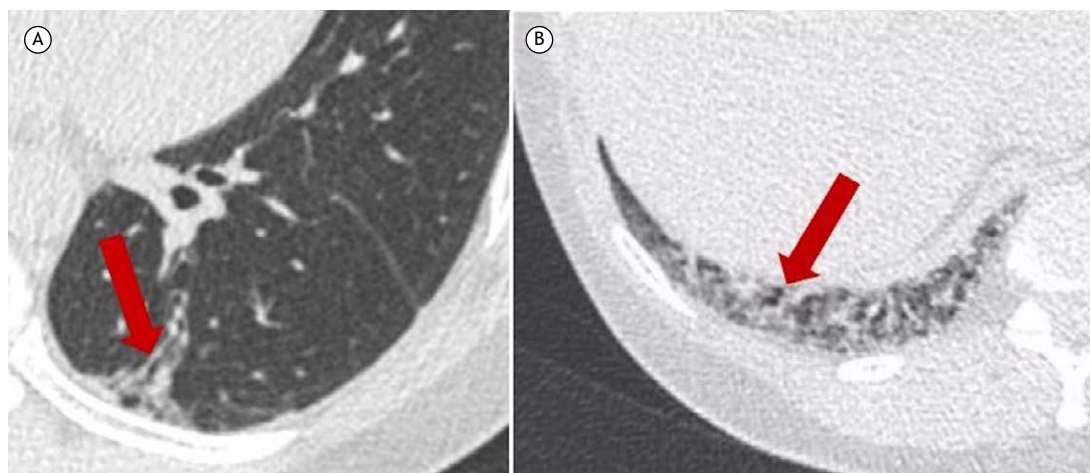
Axial CT scans with lung window settings showing traction bronchiectasis (arrow in A) and traction bronchiolectasis (arrow in B), associated with areas of lung parenchymal fibrosis.
